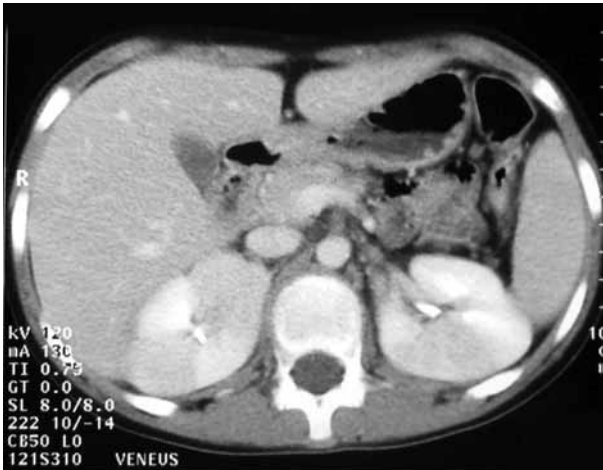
CT-scan demonstrating wedge formed lesions in both kidneys.
